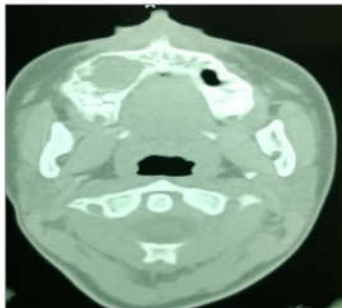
pre – operative CT SCAN of facial bones showing showed a mixed density of mass with diffuse calcifications involving right maxillary alveolar ridge and expanding the maxillary sinus with well circumscribed outline
